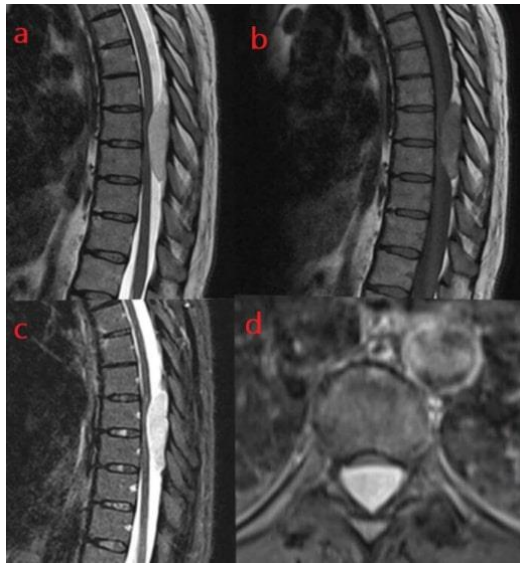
Preoperative thoracic MRI scan demonstrates extradural mass. (a) Sagittal T2-weighted MRI; (b) Sagittal T1-weighted MRI; (c) Sagittal T2 Short-Tau Inversion-Recovery (T2-STIR) MRI; (d) Axial T2-weighted MRI.
